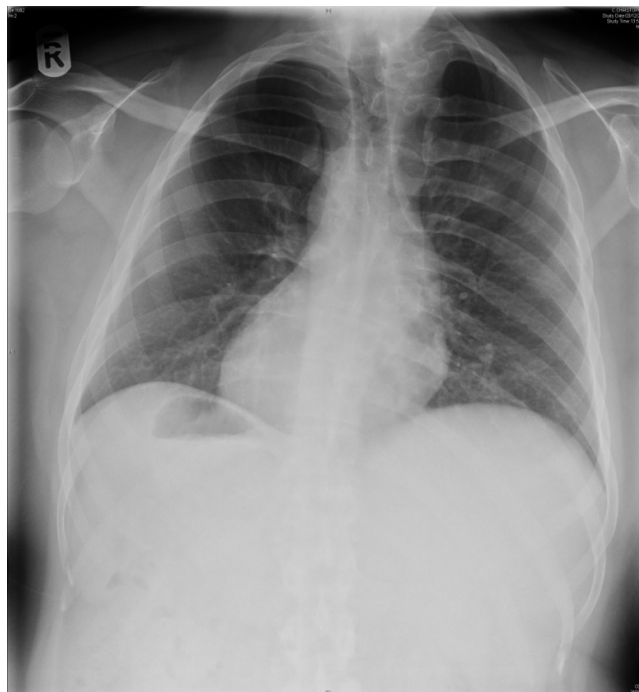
Chest X-Ray showing Situs Inversus in the patient.
